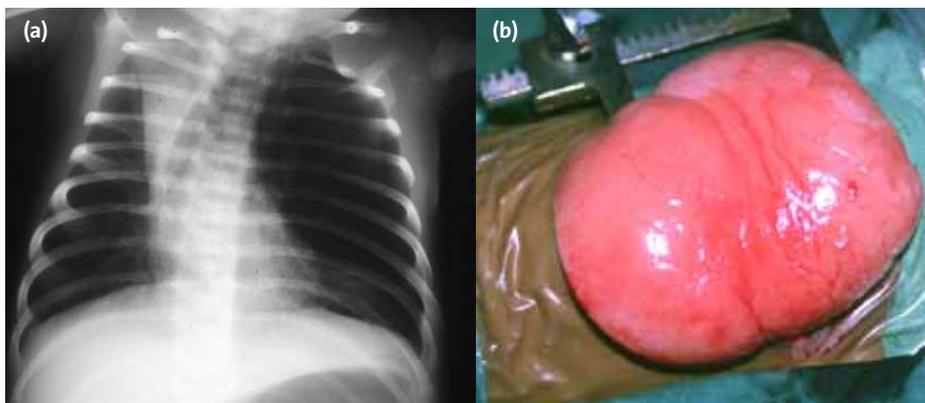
Congenital lobar emphysema. (a) Chest X-ray showing mediastinal shift and compression of the normal lung. (b) At thoracotomy the emphysematous lobe of lung is seen herniating out of the wound.
